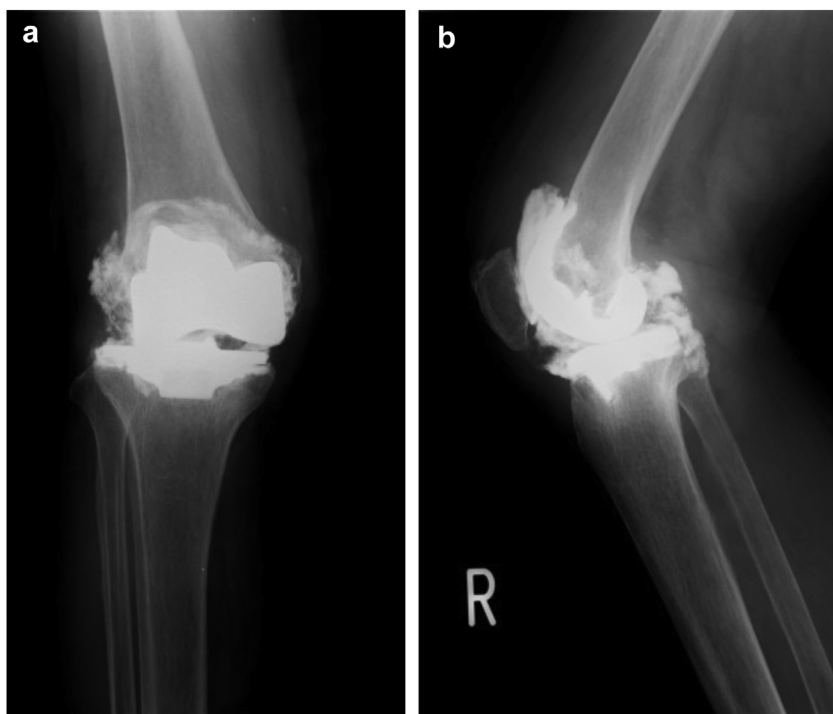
Plain radiographs at 10 months after surgery. (a) Antero-posterior view; (b) lateral view. The metal line signs associated with component shapes and thrust of the femoral component in the medial direction were observed.
